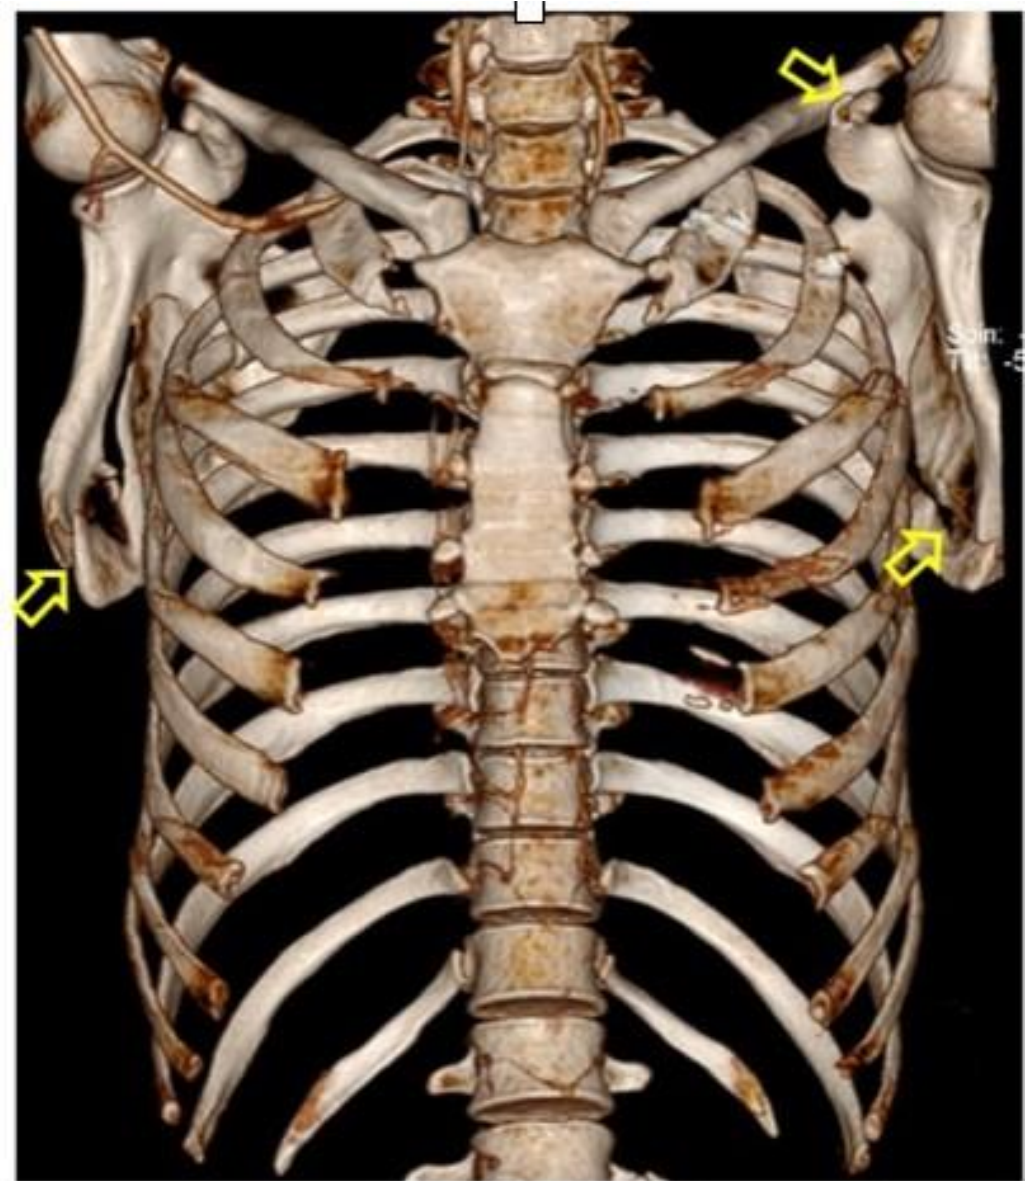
CT scan showed bilateral scapular fracture (Arrows)
